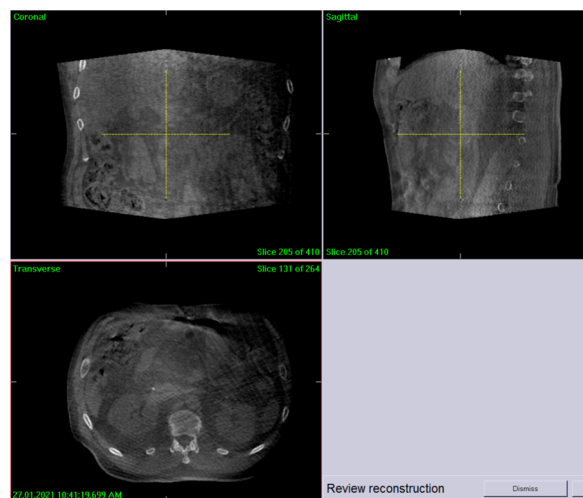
Unexpected ring artefact on the patient CBCT images
